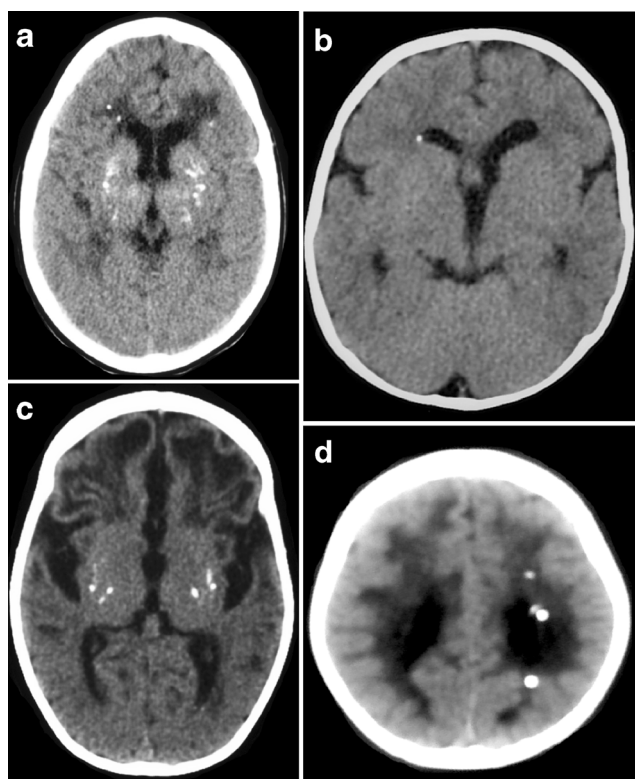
Axial CT images demonstrate patterns of calcification. a A 7-year-old girl with AGS. Axial CT image shows periventricular and basal ganglia calcifications. b A 2-year-old girl with congenital CMV. Axial CT image reveals a periventricular calcification focus adjacent to the right frontal horn of the lateral ventricles. c An 18-month-old girl with AGS. Axial CT image demonstrates basal ganglia calcification. d A 4-year-old boy with congenital CMV. Axial CT image demonstrates periventricular calcification foci adjacent to the body of the left lateral ventricle
